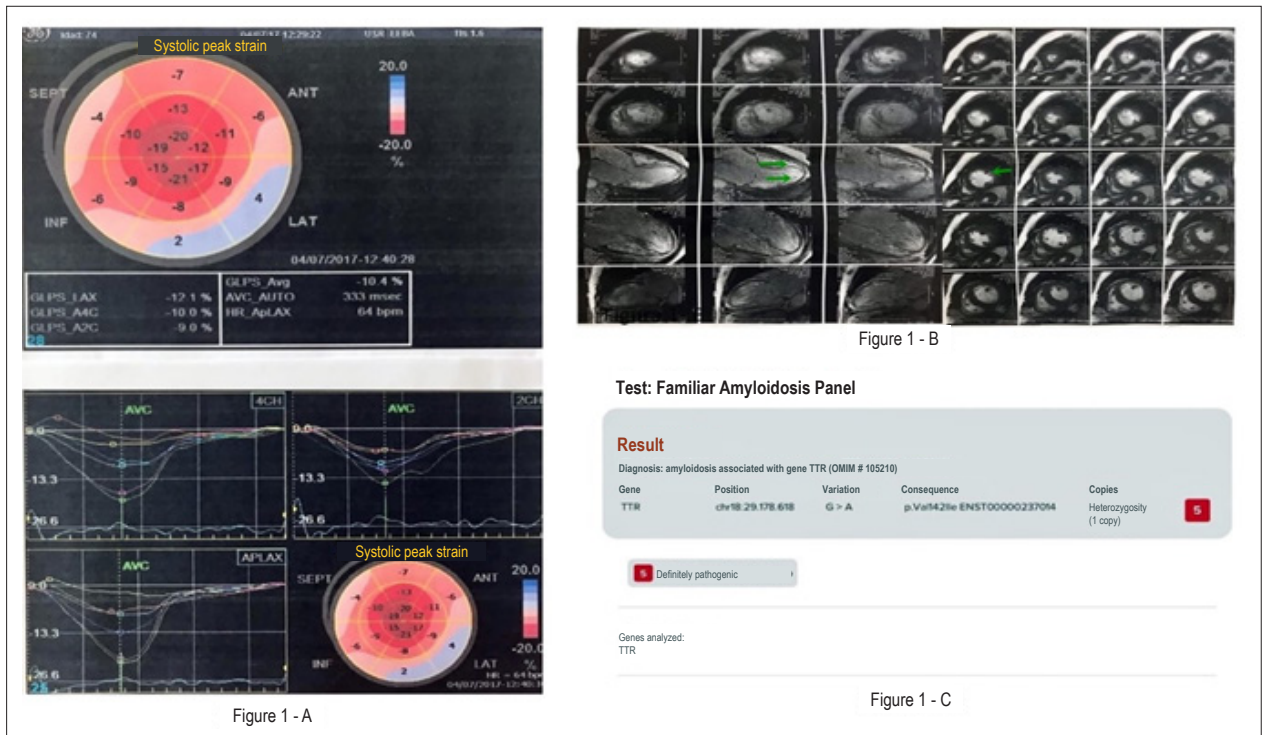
1-A) Strain echocardiography showing classic apical sparing. 1-B) MRI with diffuse heterogeneous left ventricular late enhancement (arrows on the left) and diffuse increase in LV thickness (arrow on the right). 1-C) Result of genetic study showing valine to isoleucine mutation (VAL142Ile).
